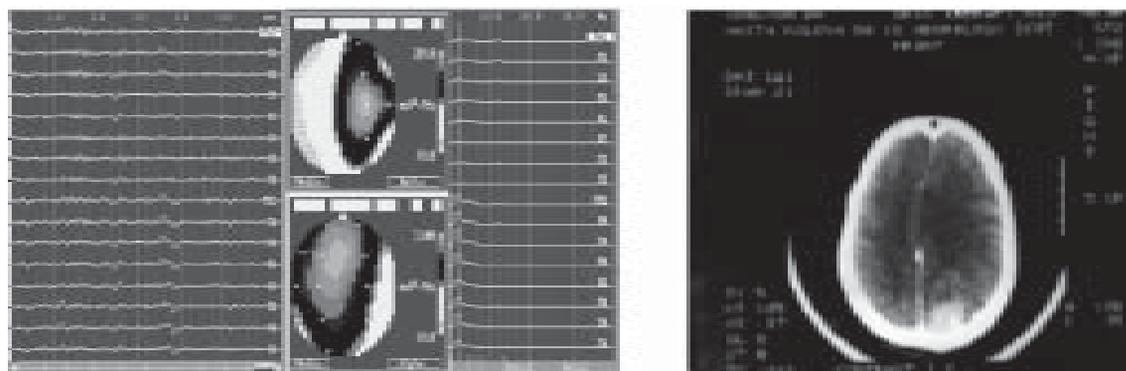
Initial EEG and CT-scan (hyperdense tumor mass in right occipital region).
